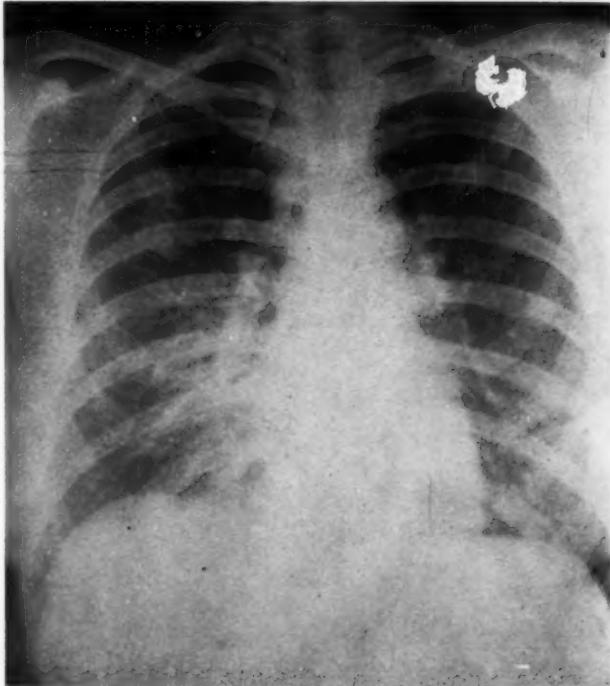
Chest roentgenogram January 19, 1957, after 4 months of streptomycin-isoniazid therapy and prior to admission to Church Home and Hospital. Evidence of increase in the upper lobe infiltrations as well as the size of the hilar lymph nodes as compared with pre-admission findings.
